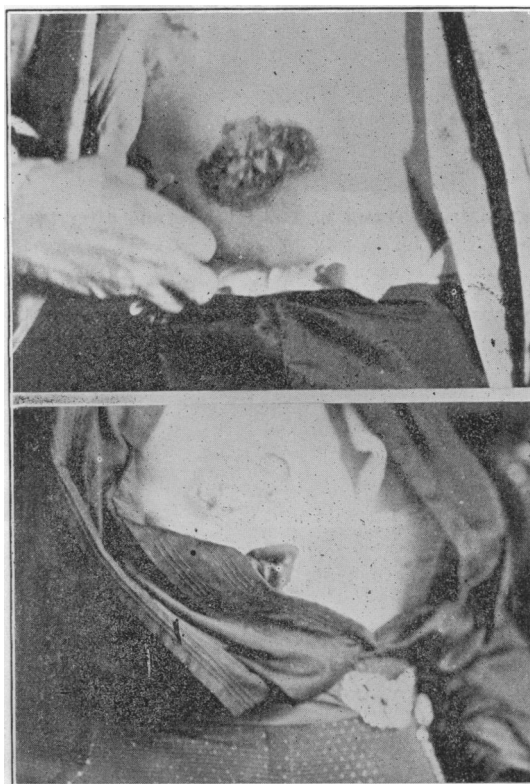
Cancer of Breast before and after Roentgenization.
